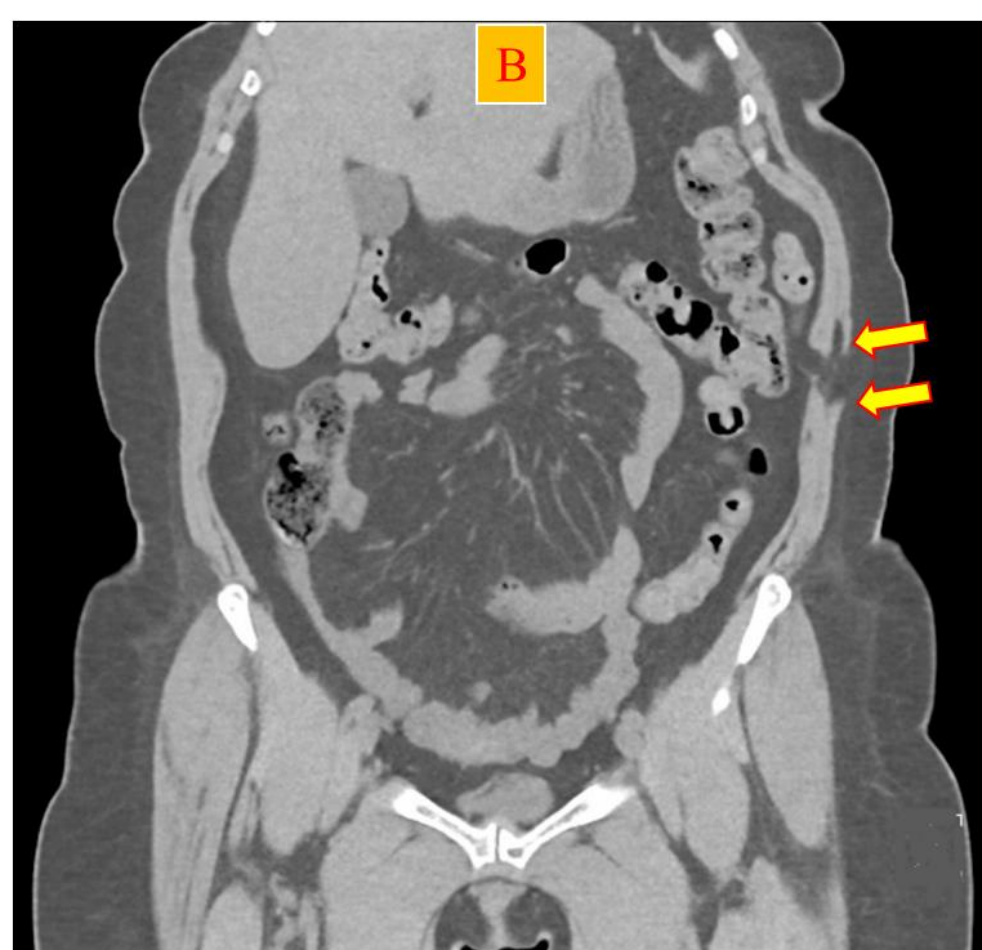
Computed tomography (CT) scan of the abdomen: (A) axial view and (B) coronal reconstruction shows port site hernia through the lateral abdominal wall defect following laparoscopic pyeloplasty (arrows showing the edges of the defect).
